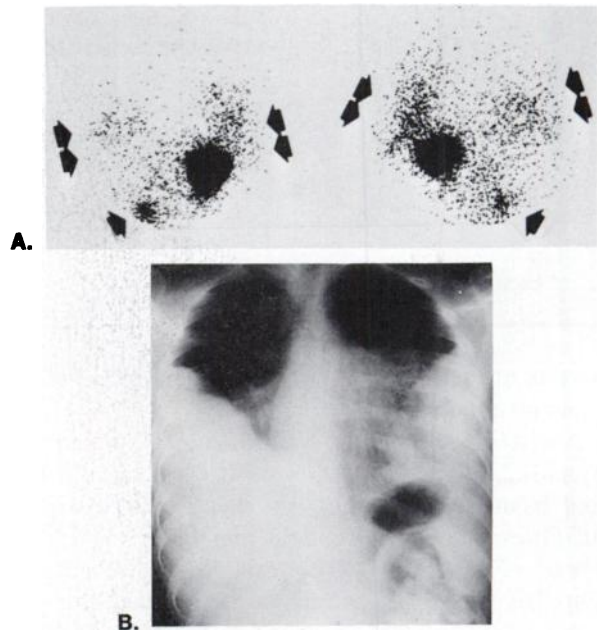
Patient R.L. (No. 1 in Table 1). (A) Anterior (left) and posterior (right) scintigrams of chest. Images have been corrected for blood-pool activity (12). There is prominent uptake of radioactive antibody in lung (double arrows) and in a discrete focal area at right lower border of liver (single arrow). Largest area of uptake, in left upper quadrant, is in stomach, which concentrated iodide liberated by breakdown of the I-131-labeled IgG. Scintigrams obtained 48 hr after injection. (B) PA chest film. Obtained at time of 48-hr scintigram shown in A. There is massive replacement of lung parenchyma inferiorly by tumor masses. Associated collapse, fluid, and possibly pneumonia, make it difficult to define precise boundaries of pleural-based masses.
